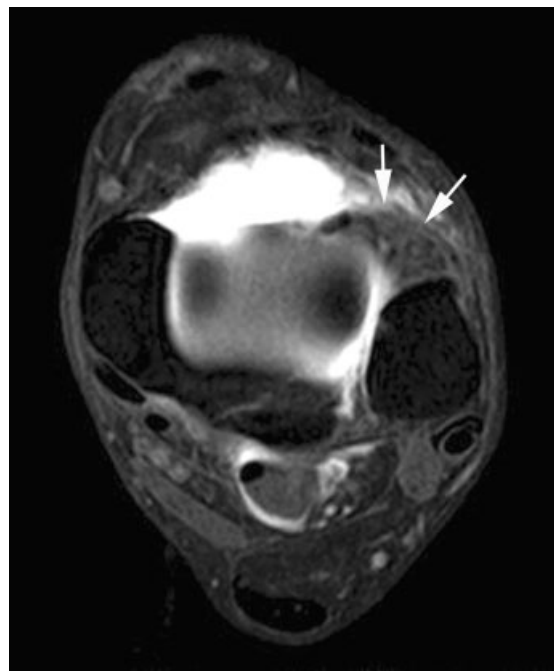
Axial fat-suppressed T1-weighted spin-echo magnetic resonance arthrogram of left ankle in a patient with anterolateral impingement syndrome demonstrates nodular lesion surrounding Bassett's ligament in the superior aspect of the anterolateral gutter (arrows). Reprinted with permission of Dr. Antonio Cruz, Santander, Spain.
